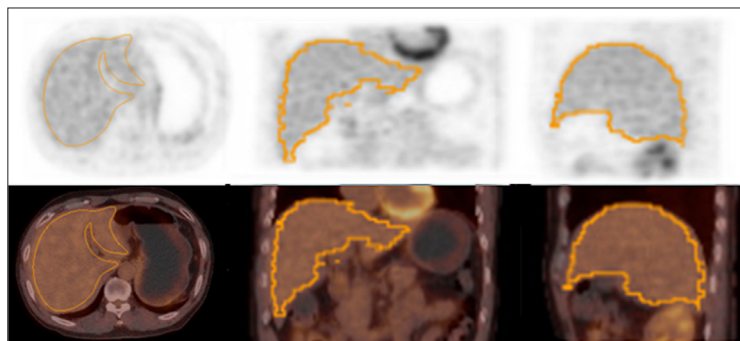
Axial, coronal, and sagittal views of regions of interest (ROIs) delineating liver boundaries are drawn manually on every axial slice to calculate hepatic volume (HV) and mean standardized uptake value (SUV_{mean}) in a whole liver. The first row are ¹⁸F-2-deoxyglucose-positron emission tomography (¹⁸F-FDG PET) of liver and the second row are fused images of PET and computed tomography (CT).
